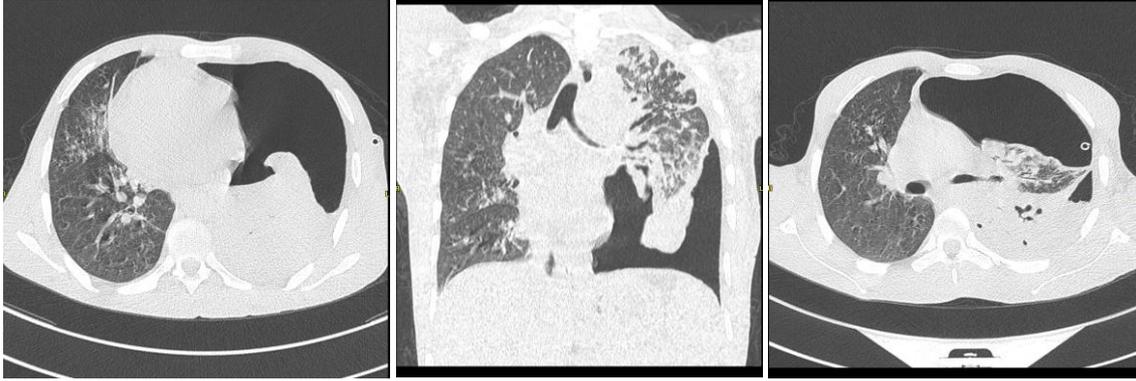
Chest CT scan in axial sections in parenchymal and mediastinal window: Large left hydropneumothorax associated with pneumonic foci complicated with abscessation and multiple branching micronodules of the right upper and middle lobe suggestive of a tuberculous origin
